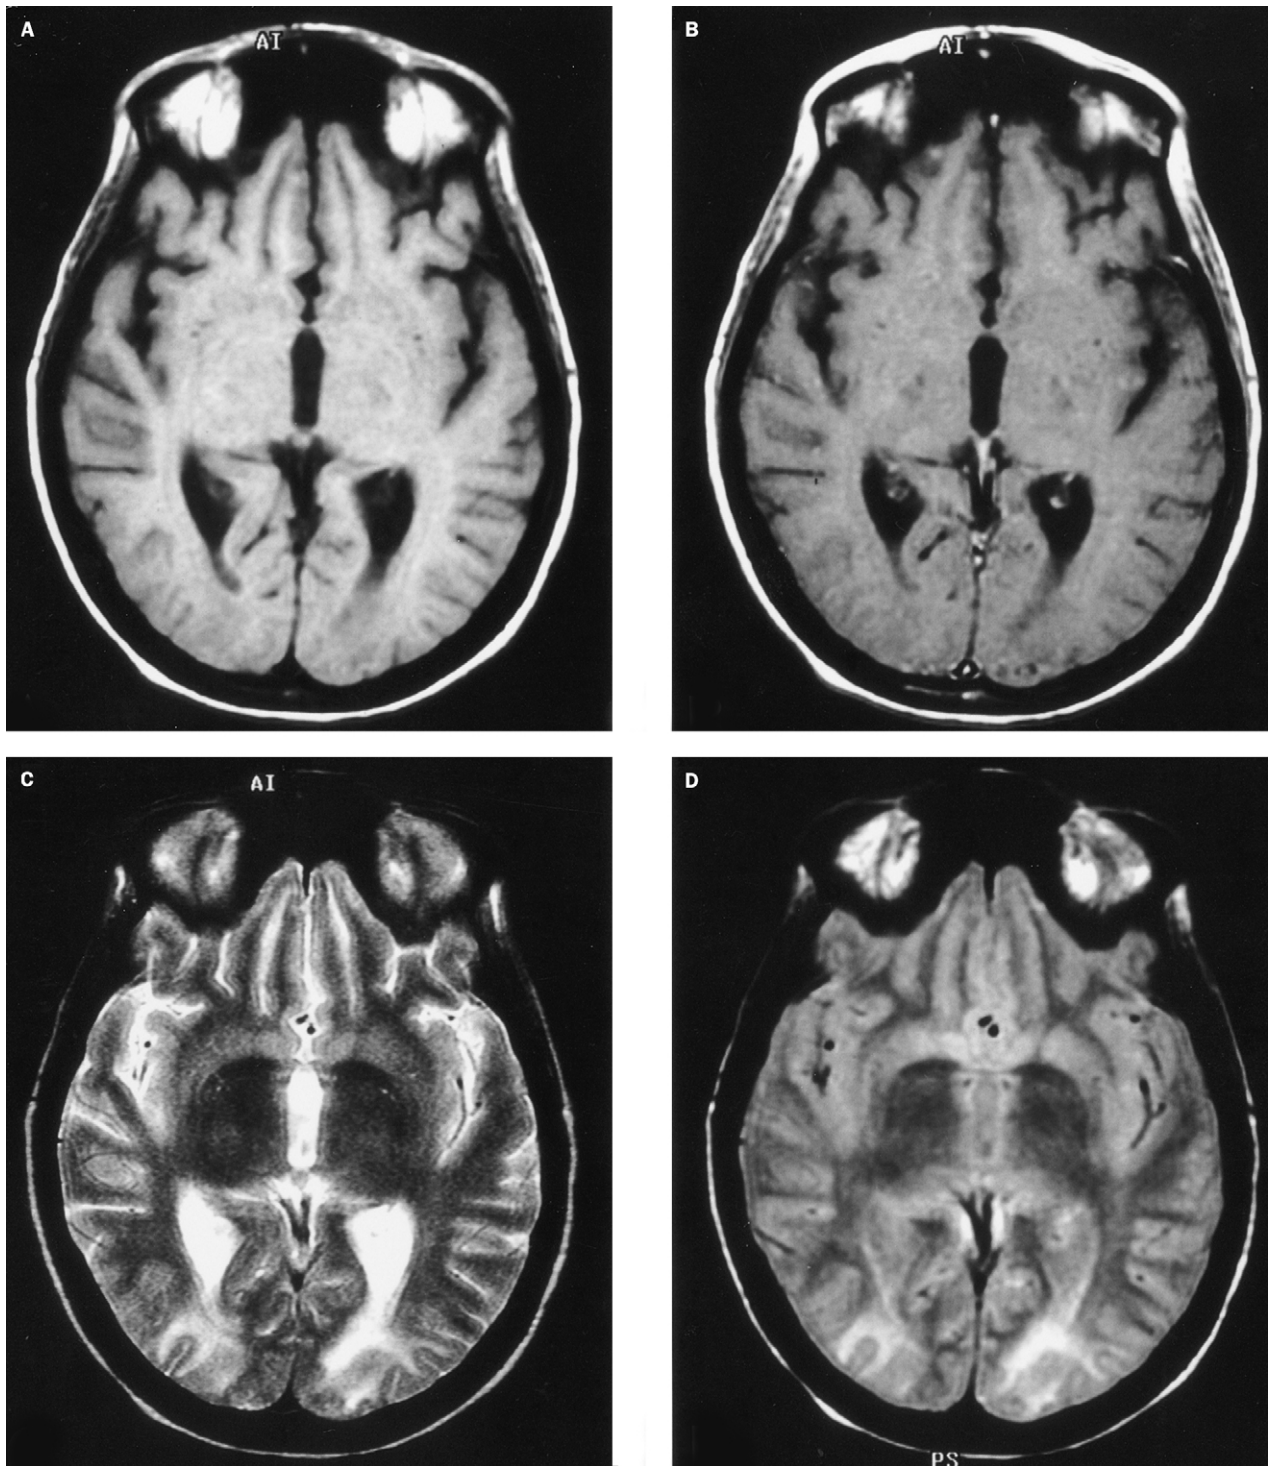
Axial magnetic resonance images of a patient with hypertensive encephalopathy
